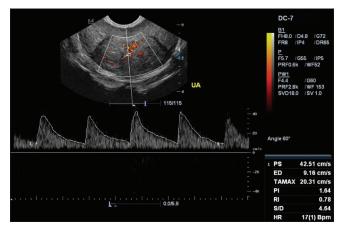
Transrectal triplex power Doppler sonogram of the urethral artery in the periurethral area of an enlarged prostate gland
